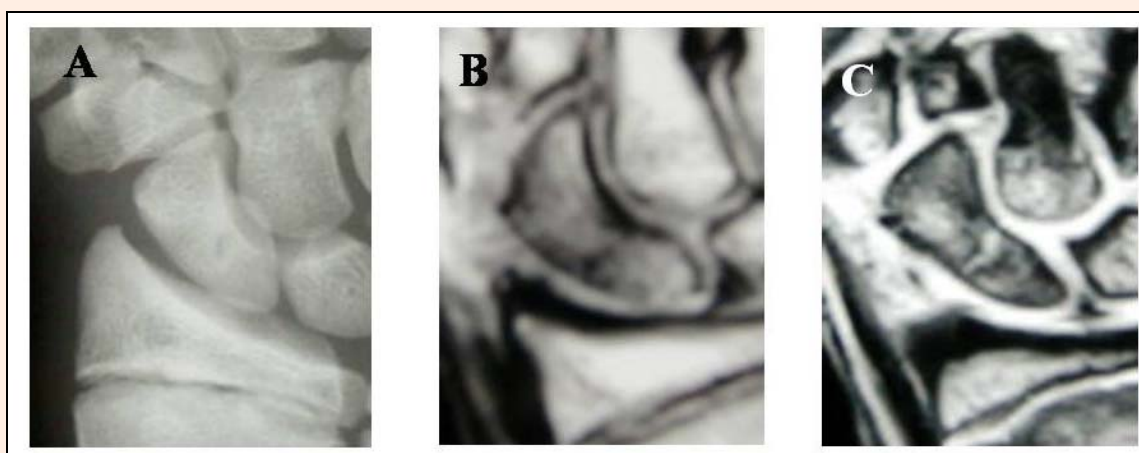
Radiograph (A) and MRI (B, C) of the right wrist at the first visit. On the anteroposterior view of the radiograph, the fracture at the waist of the scaphoid did not detected and osteophyte formation of the radial styloid process was observed (A). The low-intensity on the T1-weighted image (B) and the high-intensity on T2-weighted image (C) on MRI were observed at the waist of the scaphoid.
